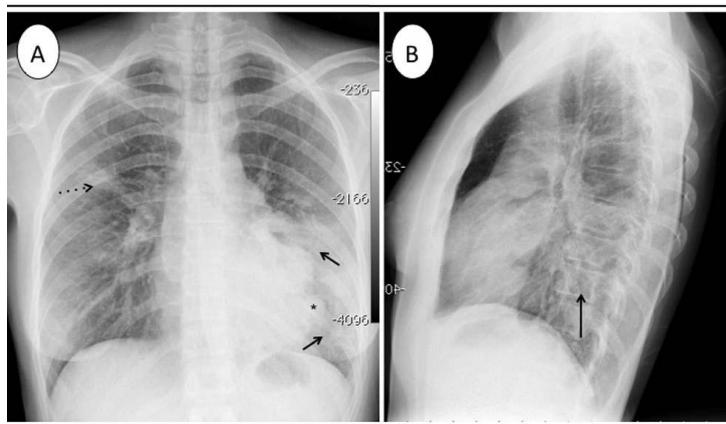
56 year old woman who complained of fever, left rib pain and malaise of 48 hours duration. Analysis found leukocytosis and increased acute phase reactants. The left paracardial hyperdensity, affecting the whole lung base on that side allows the identification of vascular structures, where a 'ground glass pattern' (arrows) can be seen. A similar picture is visible in the anterior segment of right upper lobe (dashed arrow). The patient also had a thymoma (asterisk). This chest radiography pattern, the presence of flu-like symptoms and multifocality indicates viral pneumonia. Serology confirmed the diagnosis of *Influenza NIH1*.
